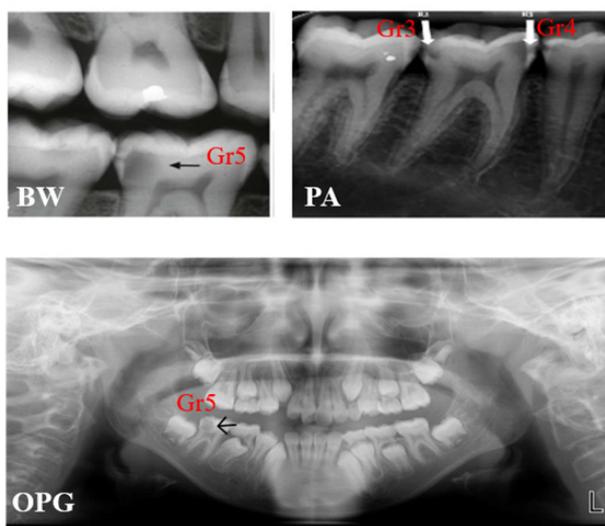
Dental radiographic images showing different stages and extent (grading) of dental caries [Bitewing (BW), Periapical (PA), Orthopantograph (OPG) and Grade (Gr)].
